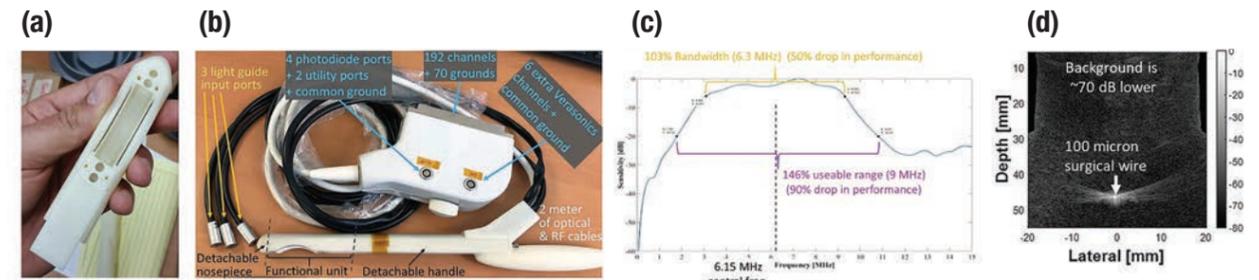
2nd generation combined photoacoustic and ultrasound imaging transducer
